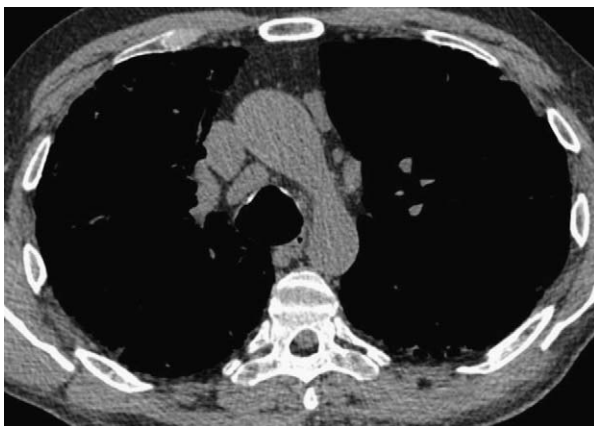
Lymph node enlargement in idiopathic pulmonary fibrosis in a 59-year-old man. Computed tomography image shows slightly enlarged paratracheal lymph node and normal size prevascular nodes.
